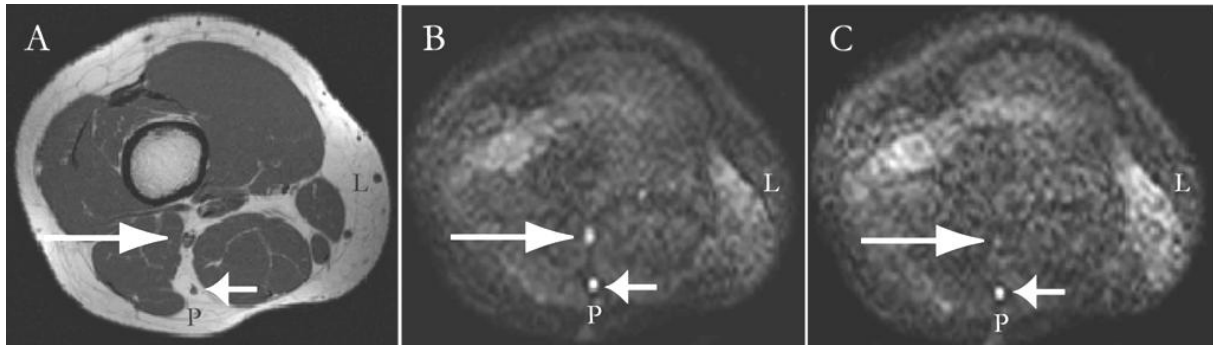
The long arrow indicates the sciatic nerve in an axial slice. The short arrow indicates a vessel. A) T1-weighted anatomical reference. B) DWI with diffusion-encoding direction perpendicular to nerve (direction 18). C) DWI with diffusion-encoding direction parallel to nerve (direction 36). L: Left; P: Posterior.
